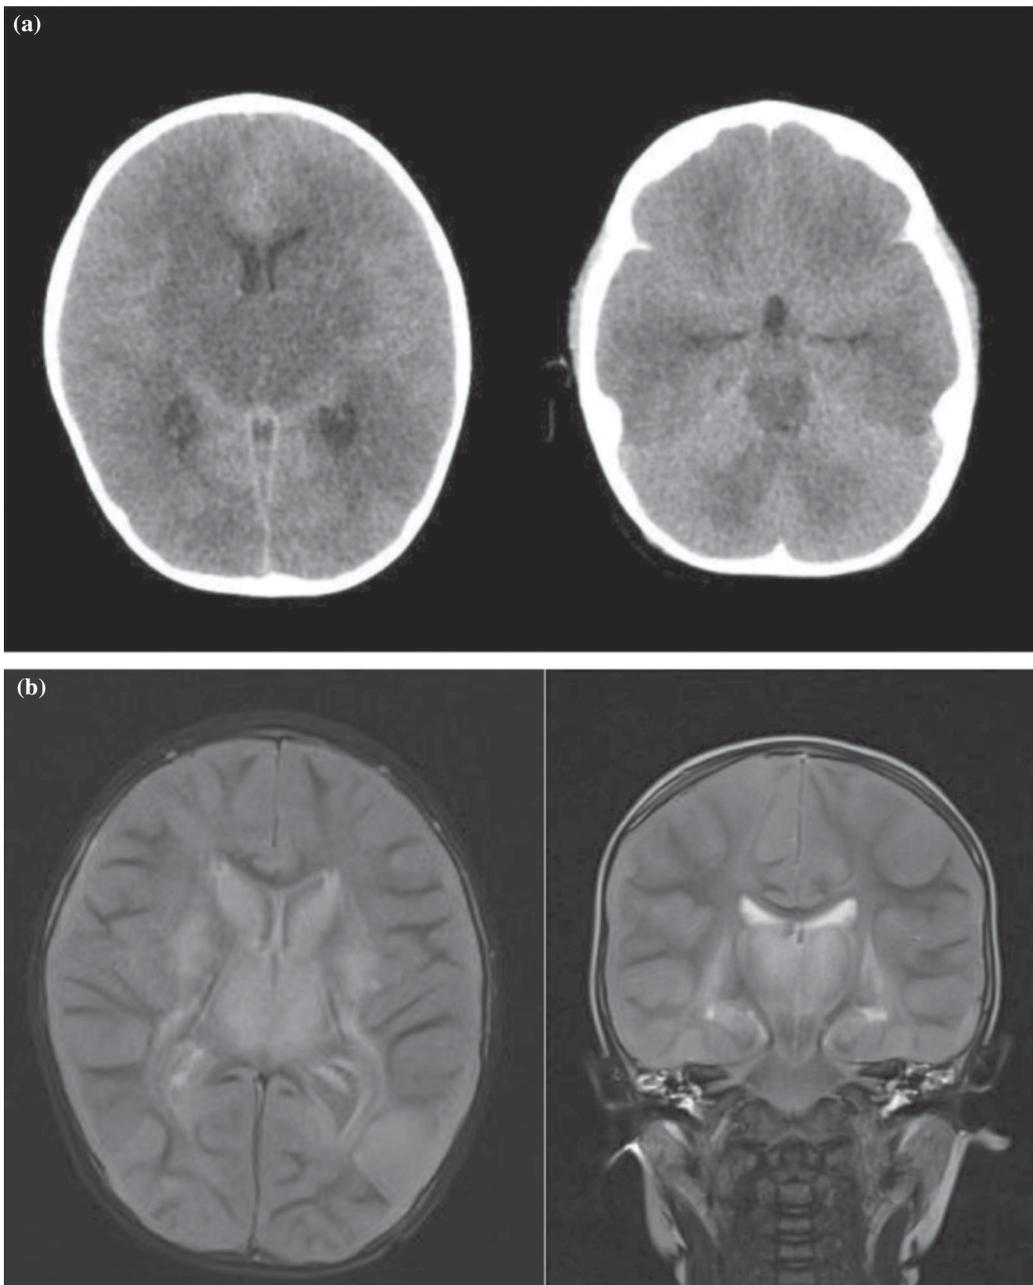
(a) CT brain of case 1 showing hypodense lesions in white matter of bilateral cerebral hemispheres, as well as in brainstem, thalami and bilateral basal ganglia. (b) MRI brain of case 1 showing multifocal lesion in basal ganglia, thalami, periventricular white matter and brain stem.
